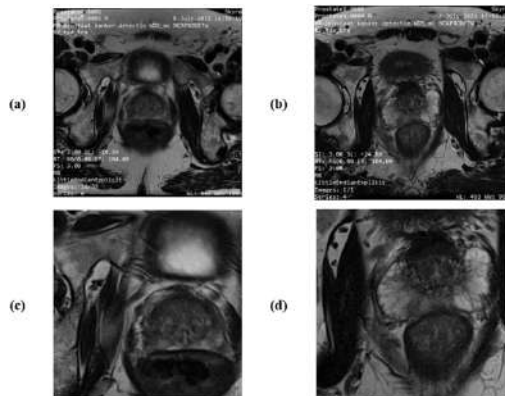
MRI images of the transversal plane. DICOM image of (a) False patient and (b) True patient. Cropped image of (c) False patient and (d) True patient
